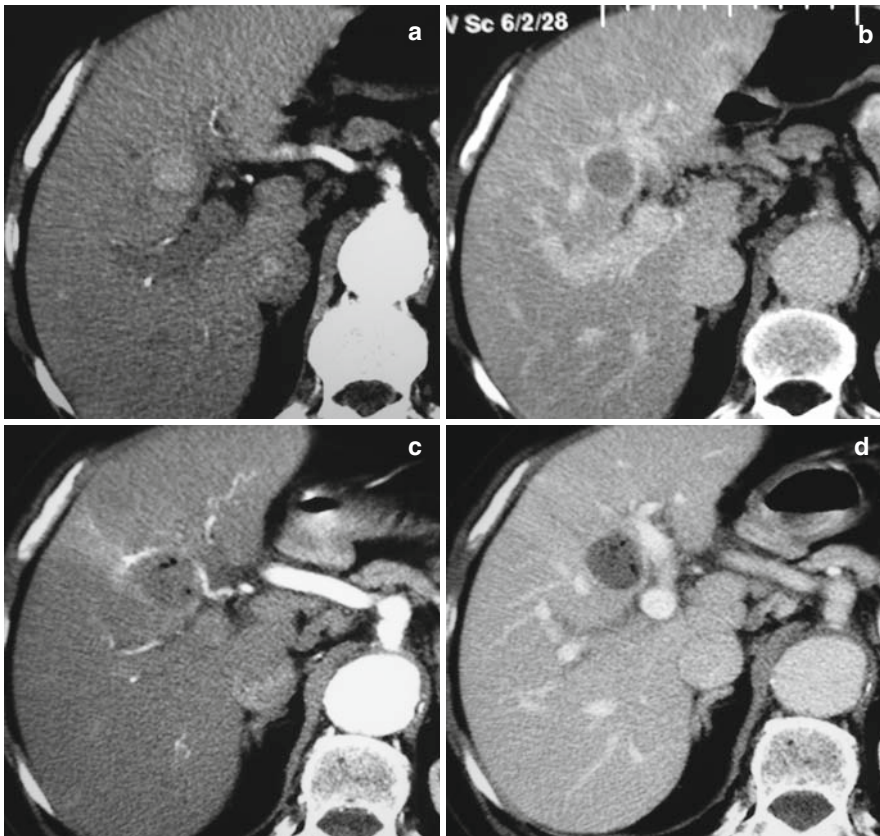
Transverse CT scans showing a HCC of 2 cm in the right lobe treated with multisession PEI. (a, b) Before treatment the tumor shows hypervascularity during the arterial phase and washout in the portal phase. (c, d) The arterial and portal phase CT scans the day after treatment show a completely necrotic lesion because of the absence of enhancement. Very small bubbles of gas due to recent necrosis are detectable inside the treated area.
